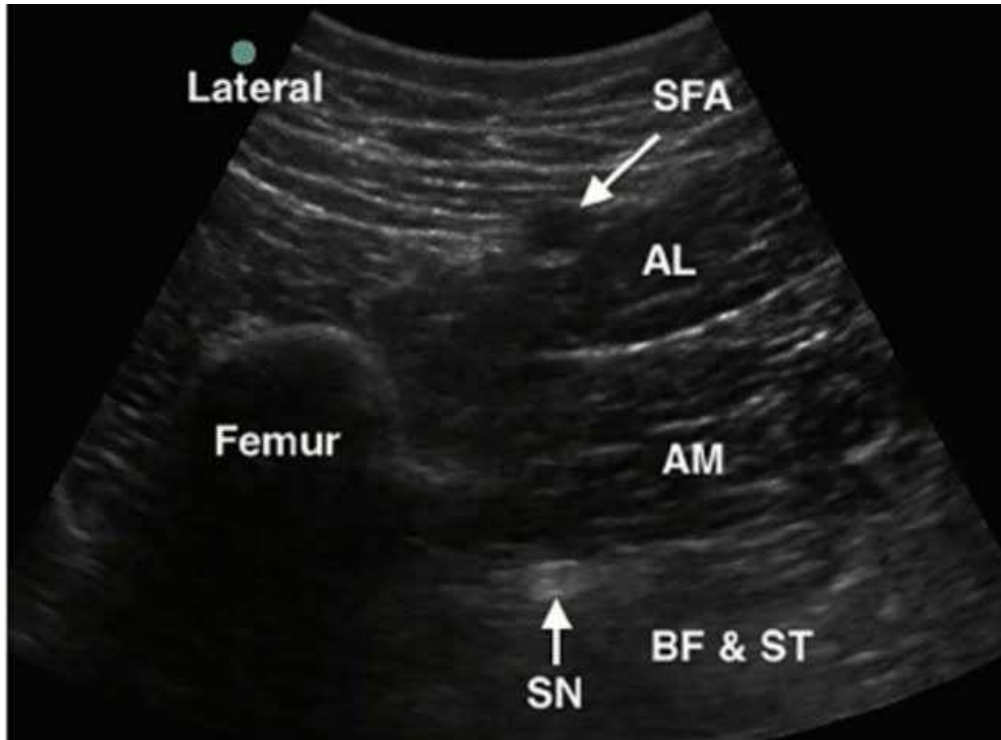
Sciatic nerve block through anterior approach via ultrasound
